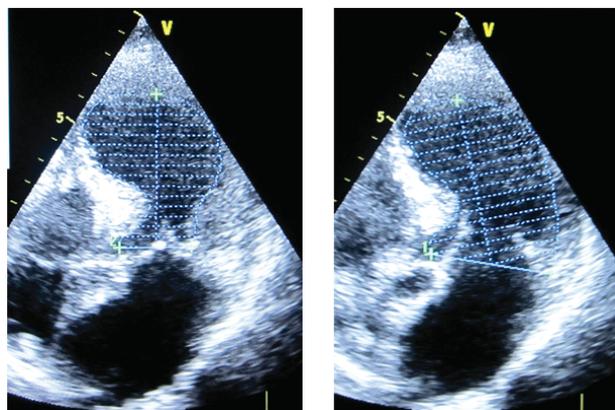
Echocardiography performed after admission, a 4-chamber apical view in systole and diastole.
